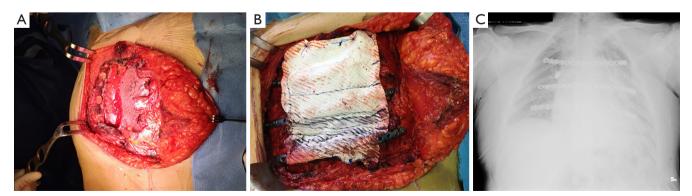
Surgical outcome. (A) The defect of the chest wall after sternectomy; (B) the sandwich prosthesis in situ after positioning and fixing at the ribs completely covering the sternum defect; (C) the post-operative chest X-ray showing the final results of the technique.
